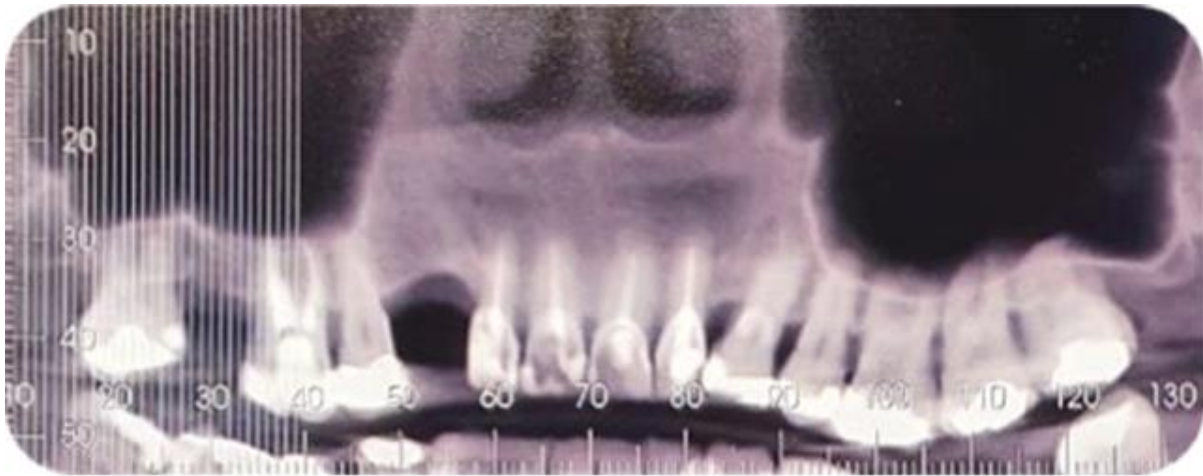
Primary orthopantomography, highlighting the bone defect to be reconstructed.
